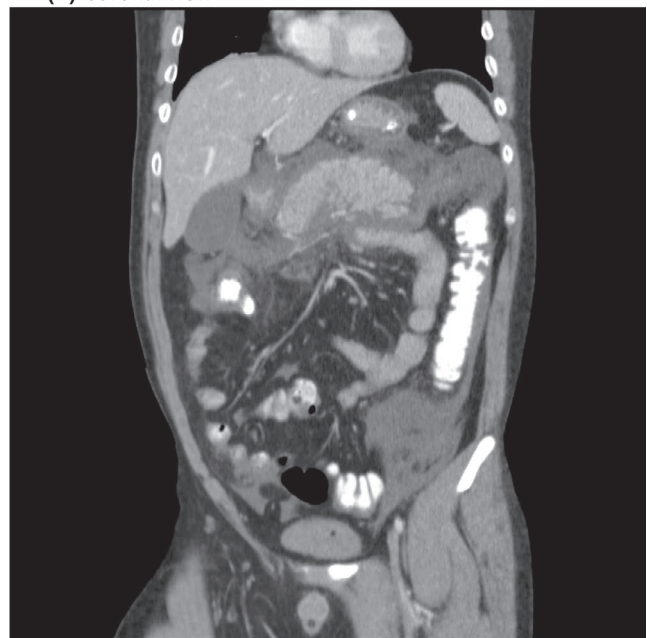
Abdominal CT scan findings revealed interstitial edema without necrosis, hemorrhage, or abscess in the pancreas (a. cross-sectional view and b. coronal view)
